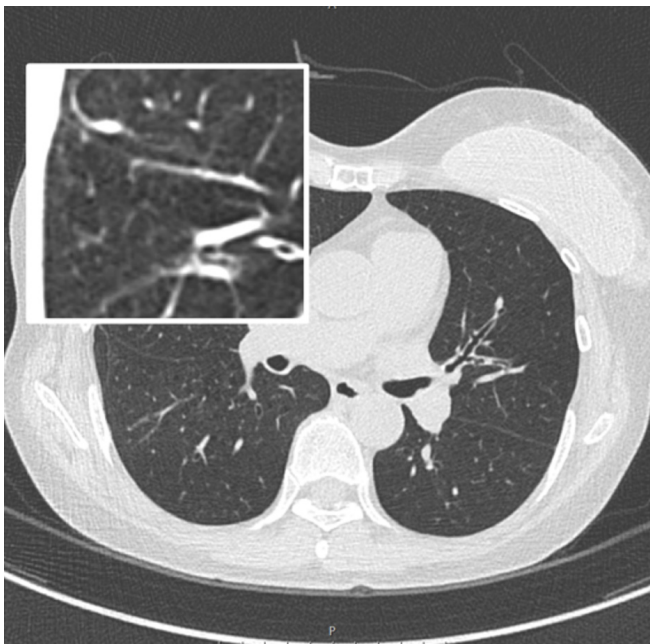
The chest computed tomography scan shows diffuse bronchial wall thickening, air-trapping, and mild emphysema in both lungs. A magnified view of the region demonstrating prominent centrilobular emphysema is inserted in the upper left portion and outlined in white.
